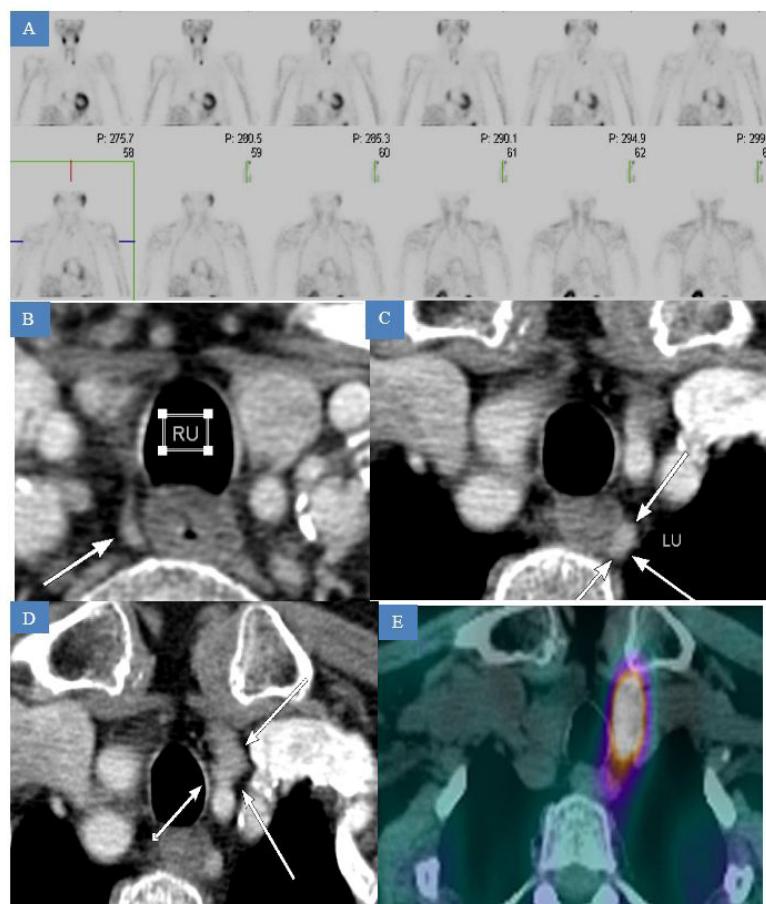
Images from an 80-year-old woman with primary hyperparathyroidism. Coronal MIBI images (A) demonstrate that the only MIBI avid gland was in the left lower quadrant. The three 4DCT images (B-D) show enlarged and enhancing glands in the right upper, left upper and left lower quadrants, respectively. All three abnormal glands on 4DCT were diseased glands on pathology. The 4DCT-MIBI-SPECT imaging (E) demonstrates the combination of 4DCT and MIBI-SPECT technologies in the diseased left lower quadrant.
